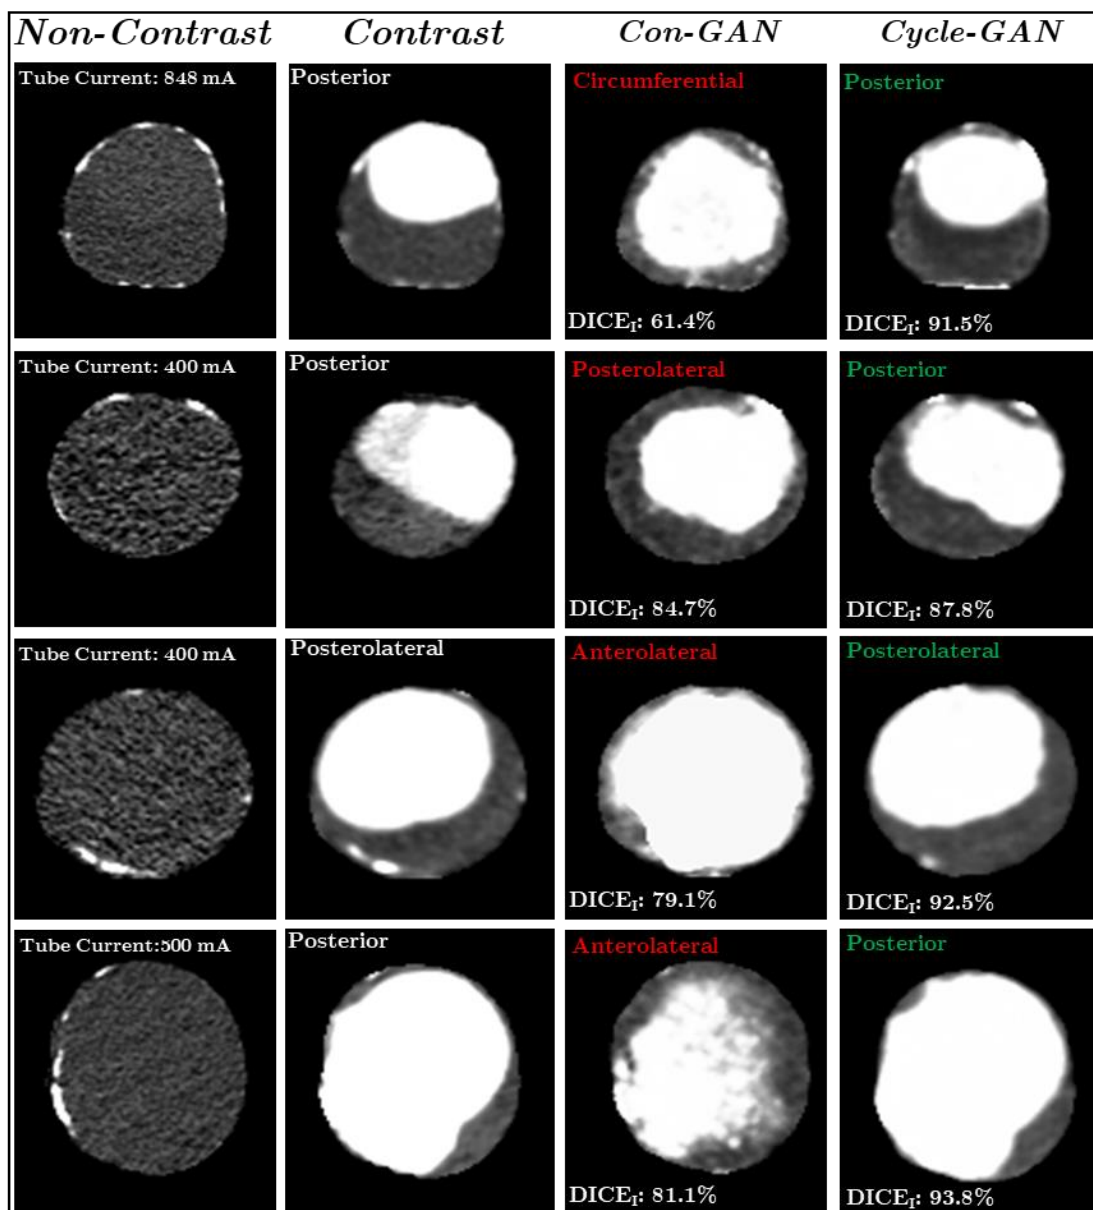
Points of discrepancy between the Con-GAN and Cycle-GAN Models. Axial images of four patients within the [OxAAA-IMG-I dataset](#) are displayed where the Con-GAN fails to properly classify the OWS. However, the Cycle-GAN is able to properly classify the OWS. Corresponding x-ray tube currents and DICE scores are highlighted within each panel¹¹.
